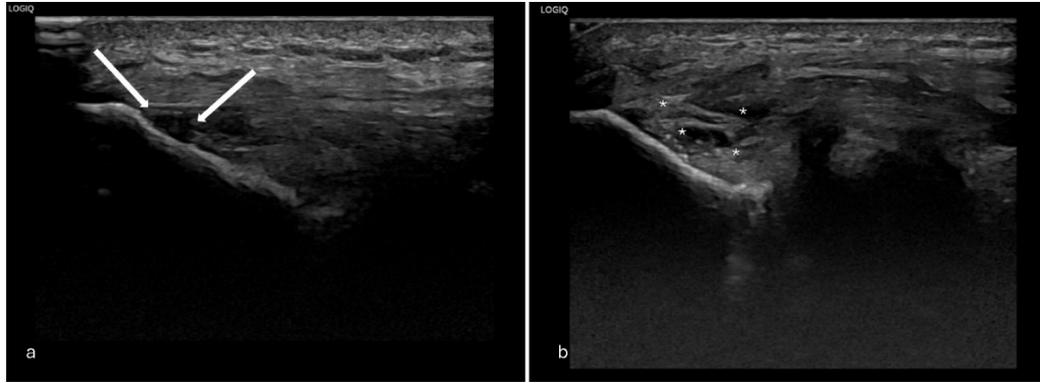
Sagittal B-mode ultrasonographic images of the common extensor tendon showing structural abnormalities, including a hypoechoic area consistent with mucoid degeneration (a, white arrows) and disruption of the normal fibrillar architecture (b, white asterisks).
